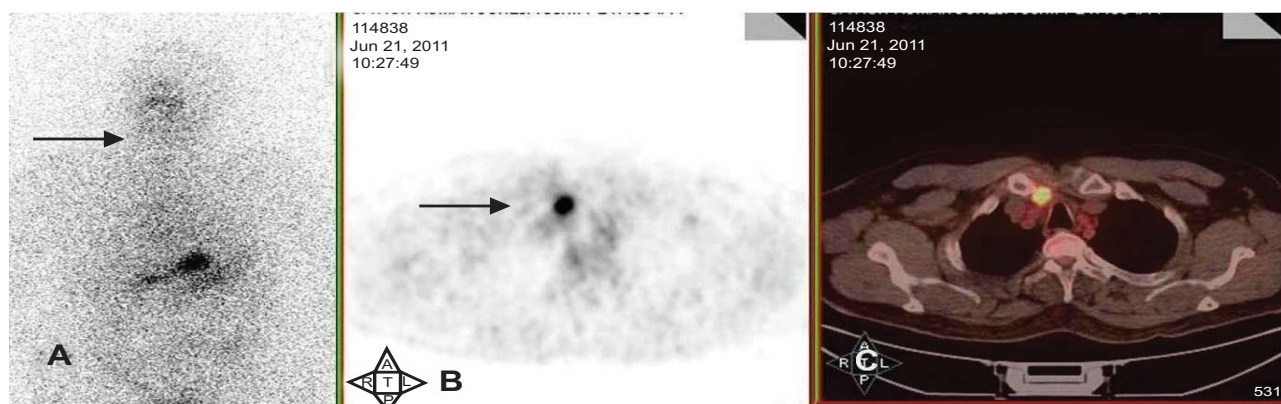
A case of radioiodine refractory thyroid cancer where I-131 scan is negative (A) & disease is seen in FDG PET (B & C)
